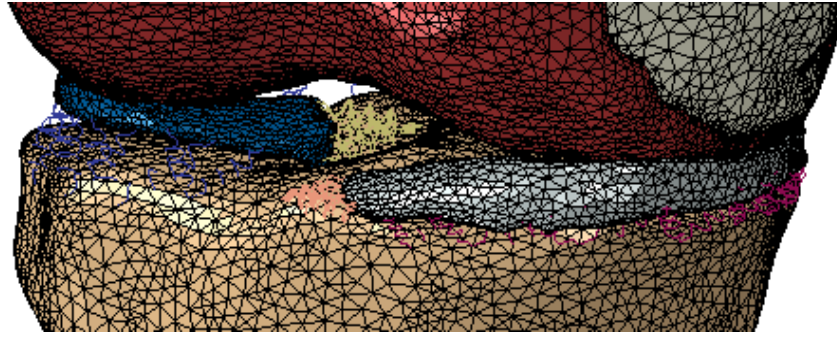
3D rendering of the full joint contact model which includes femur, femoral AC, lateral meniscus, medial meniscus and tibia reconstructed from MR image scan data. Meniscal horn attachments and MTLs are modelled using springs.
